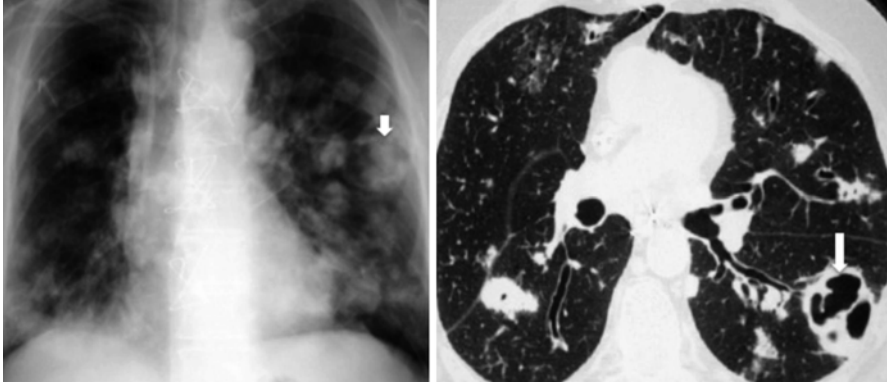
CXR and CT on a 30 year-old male intravenous drug abuser with multiple bilateral septic infarcts. The largest of the cavities in the left lung (*block arrow*) has intracavitary soft tissue and air, proven to be aspergillus
